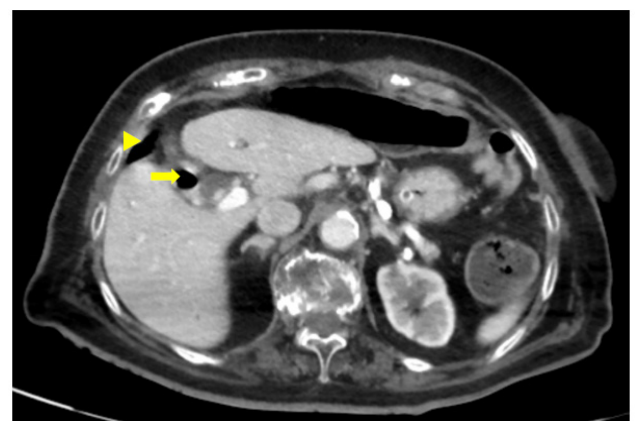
Abdominal and Pelvic CT showing an undefined gallbladder with an air level in its topography (arrow) adjacent to a large bowel loop (arrowhead), raising suspicion for a cholecystocolonic fistula. CT: computed tomography.
